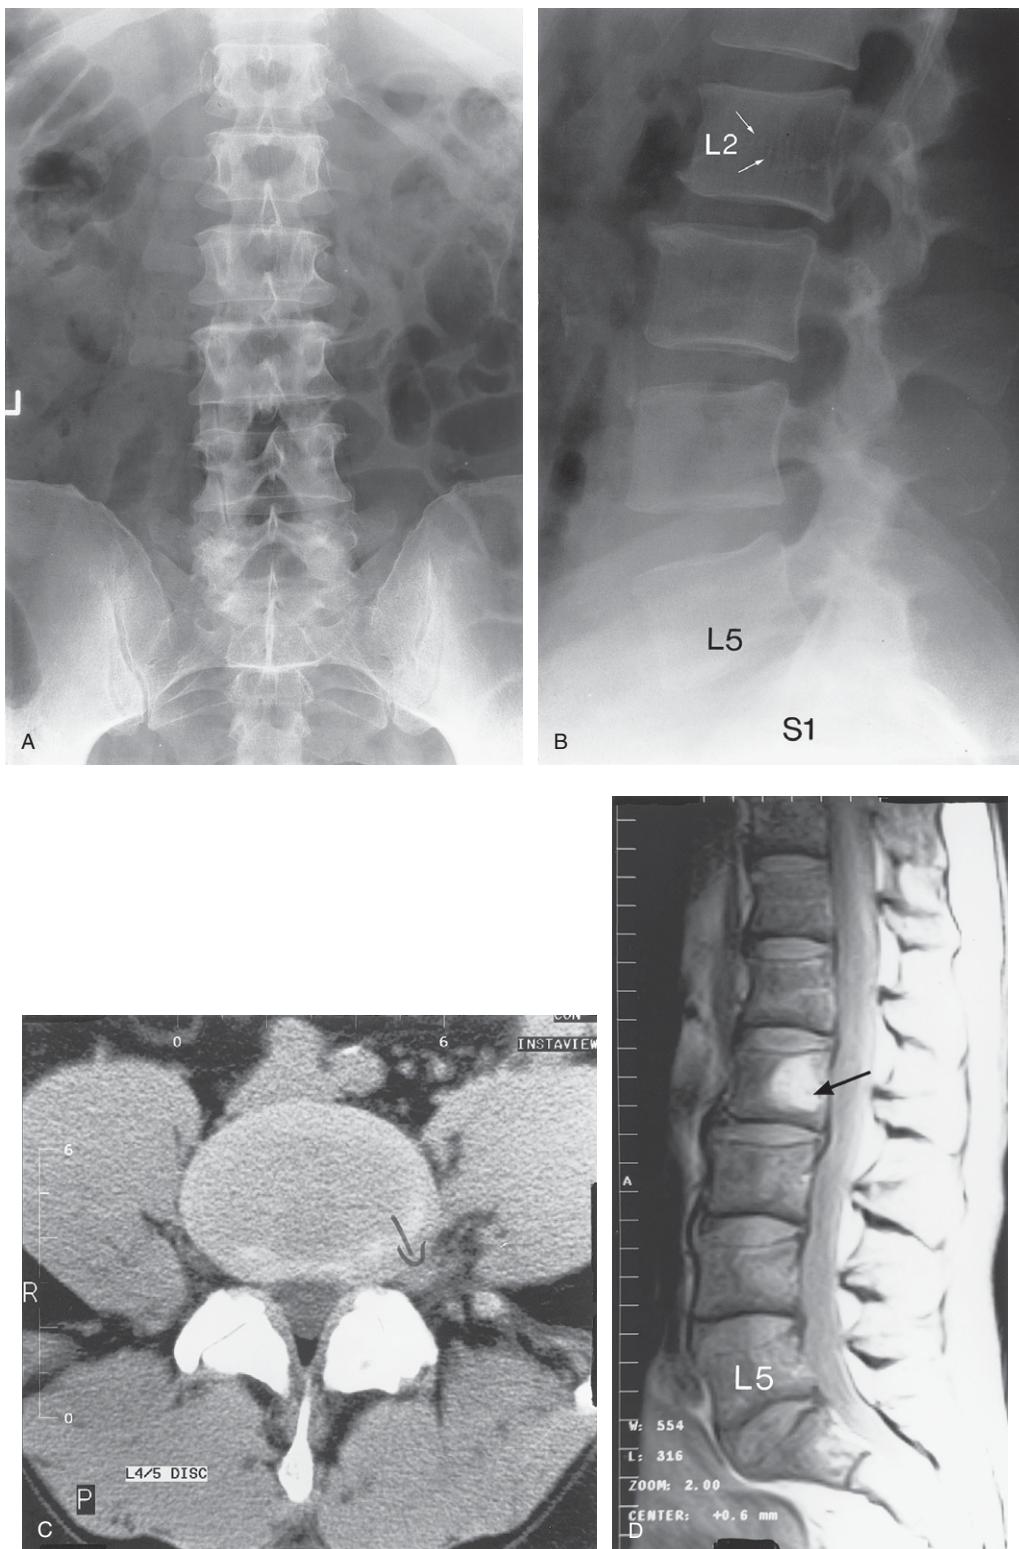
(A) Lumbosacral spine anteroposterior plane X-ray image showing minor lipping of most vertebral bodies and tropism of some zygapophysial joints. L = left side of patient. (B) Lumbar spine lateral plane X-ray image showing some thinning of the L2–3 intervertebral disc with lipping anteriorly on the adjacent bony margins and some retrolisthesis of L2 on L3 vertebra. Note the vertical 'corduroy' trabecular pattern in the L2 body (arrows) indicating a haemangioma. L5 = fifth vertebral body; S1 = first sacral segment. (C) Lumbar spine CT axial image at the L4–5 disc level showing a possible left far lateral L4–5 disc protrusion or a tumour of neural origin (arrow). P = posterior side of patient; R = right side of patient. (D) Lumbosacral spine MRI sagittal T1-weighted image showing the haemangioma (arrow) involving the L2 vertebral body with some posterior bulging of the L2–3 intervertebral disc.
